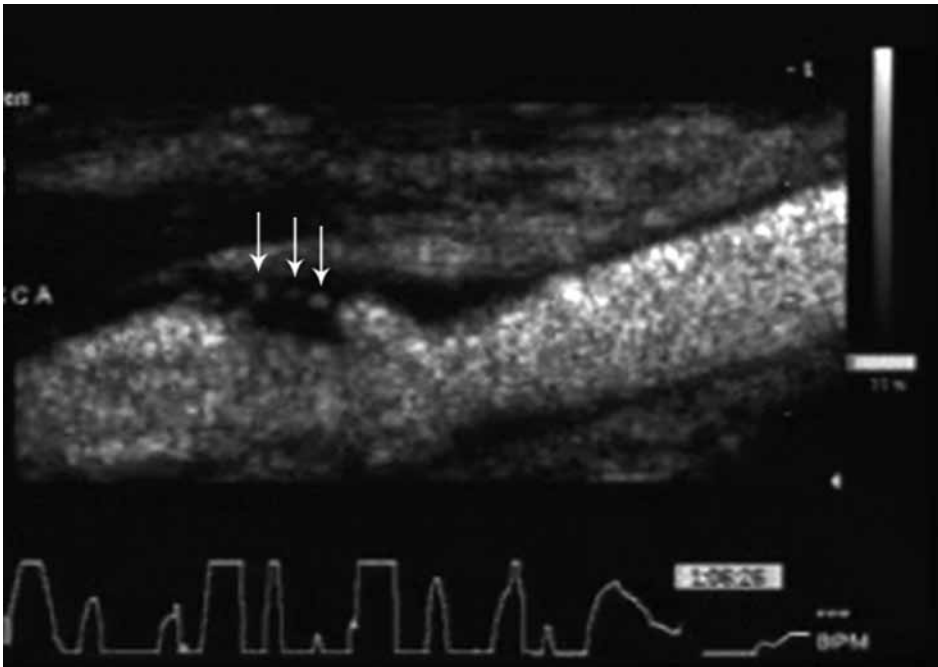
Contrast-enhanced ultrasound image of the common carotid artery with an ulcerated atherosclerotic plaque in the carotid bulb. Individual microbubbles can be seen in the plaque (arrows) indicating intraplaque vasa vasorum.
